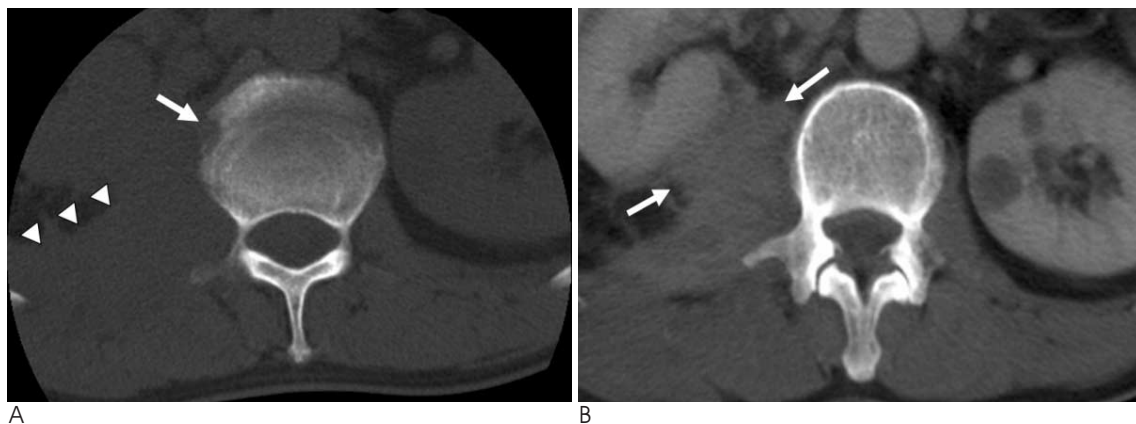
A. The lumbar spine CT showing the right paraspinal mass lesion (arrow heads) with marginal erosion of the L1 vertebral body (arrow). B. The contrast-enhanced CT scan showing a bulky mass with relatively homogenous enhancement that crosses the posterior pararenal fascia and extends to the renal cortex (arrows).
